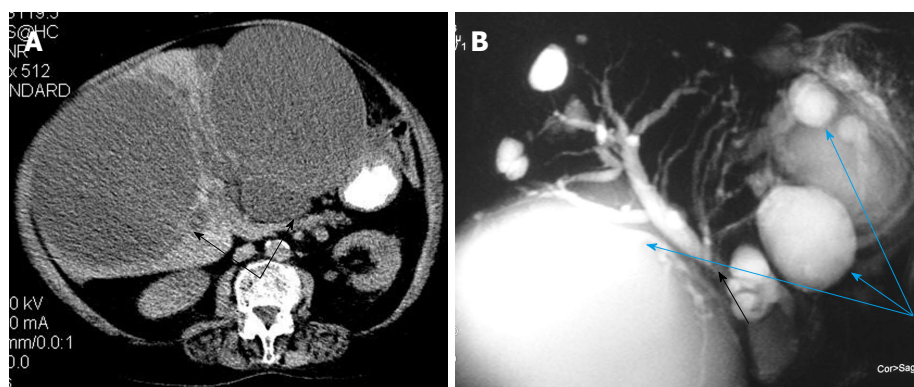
Image. A: Computed tomography image in a case of multicystic disease, showing two large dominant cysts causing mild intrahepatic biliary dilatation (black arrows); B: Magnetic resonance cholangiopancreatography image shows multiple hepatic cysts (light blue arrows) while the common bile duct seems compressed between the two larger cysts (black arrow).
